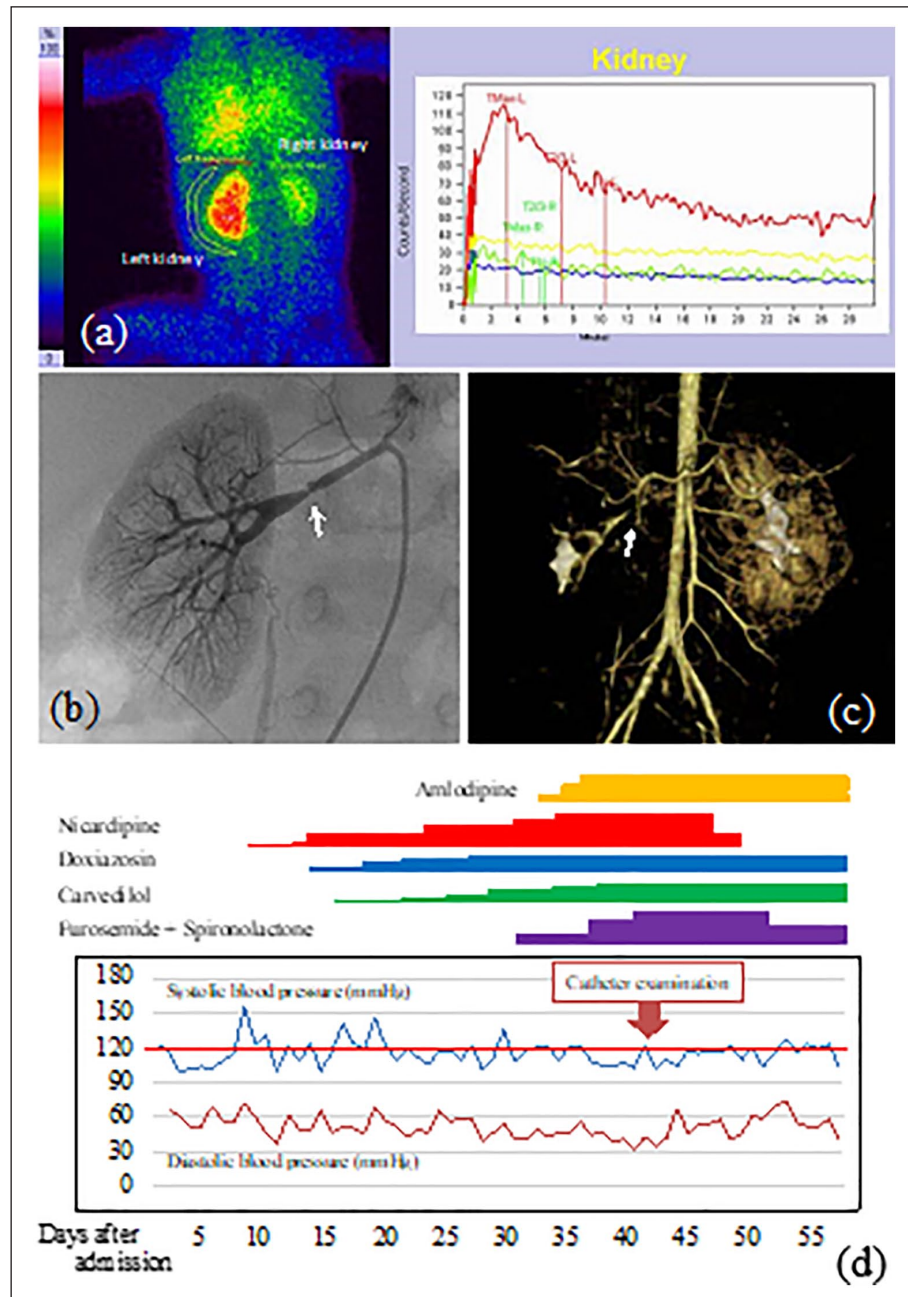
The imaging findings of our patient. (a) Diuresis renogram shows a high dysfunction of the right kidney. Red and green lines show function of the left and right kidney, respectively. (b) Three-dimensional computed tomography angiography (3DCTA): right renal artery stenosis. (c) Angiography: the right renal artery showed a stenosis at 2/3 of the site from the aorta to branch (white arrows). (d) The clinical course after admission just before catheter therapy: hypertension appeared at day 9, which lasted after administration of several anti-hypertension drugs. We examined the catheter angiography and found a right renal artery stenosis. He underwent balloon catheterization for the stenosis of the renal artery to another hospital.
